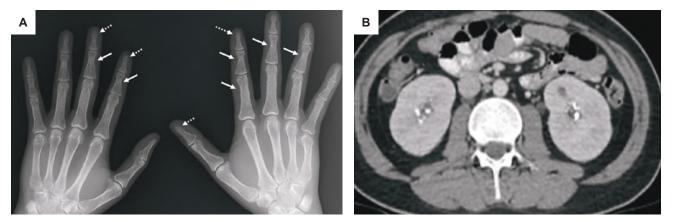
Complications of primary hyperparathyroidism. (A) Radiograph of both hands showing subperiosteal bone resorption at the radial aspects of the proximal and middle phalanges *(solid arrows)* and at the tufts of the distal phalanges *(dotted arrows)*. (B) Axial contrast-enhanced computerized tomography scan of the kidneys showing bilateral non-obstructing calyceal calculi.
